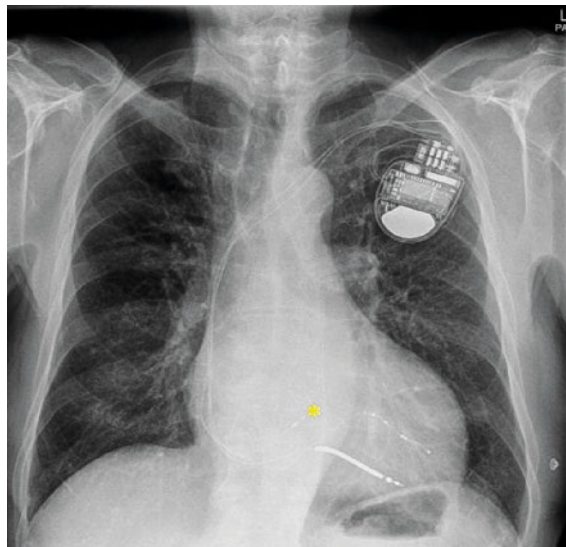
Chest x-ray in postero-anterior view. Cardiac resynchronisation therapy-defibrillator device with right ventricular shock lead, quadripolar lead in a posterolateral side branch of the coronary sinus and His pacing lead (yellow asterix).
